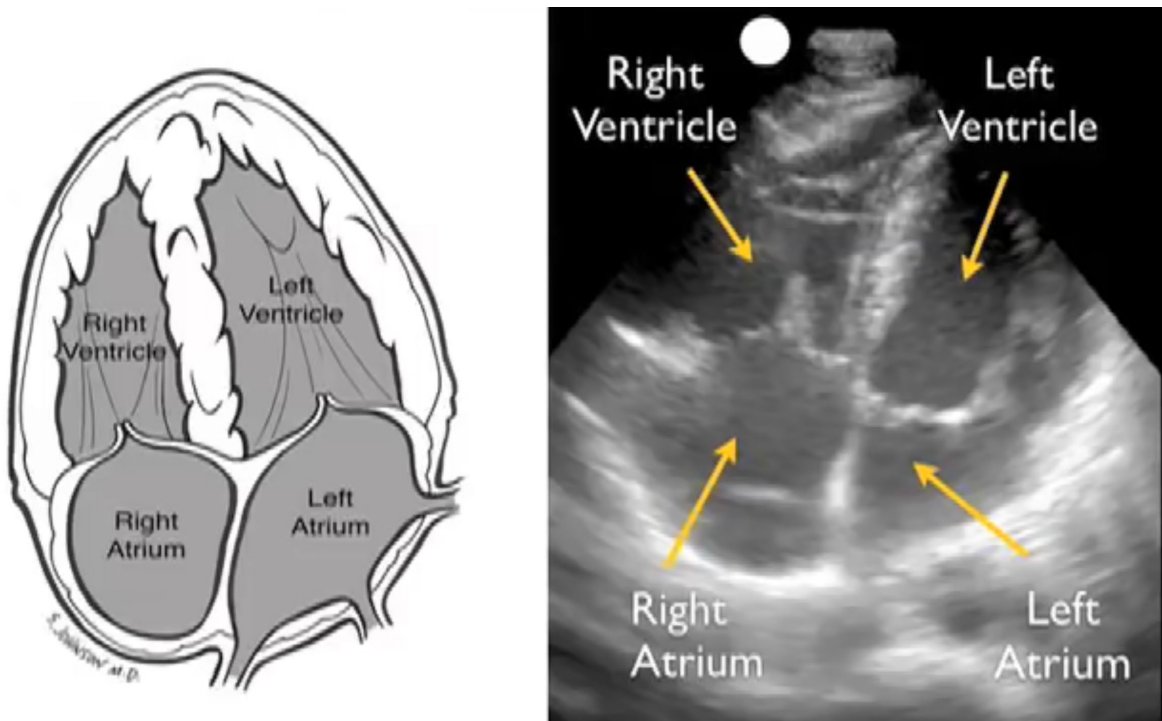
Orientation of the heart during the cardiac ultrasound. The heart is upside down and backwards, with the left atrium shown in the bottom right corner and the right atrium in the bottom left corner. (Sonosite, 2010).
